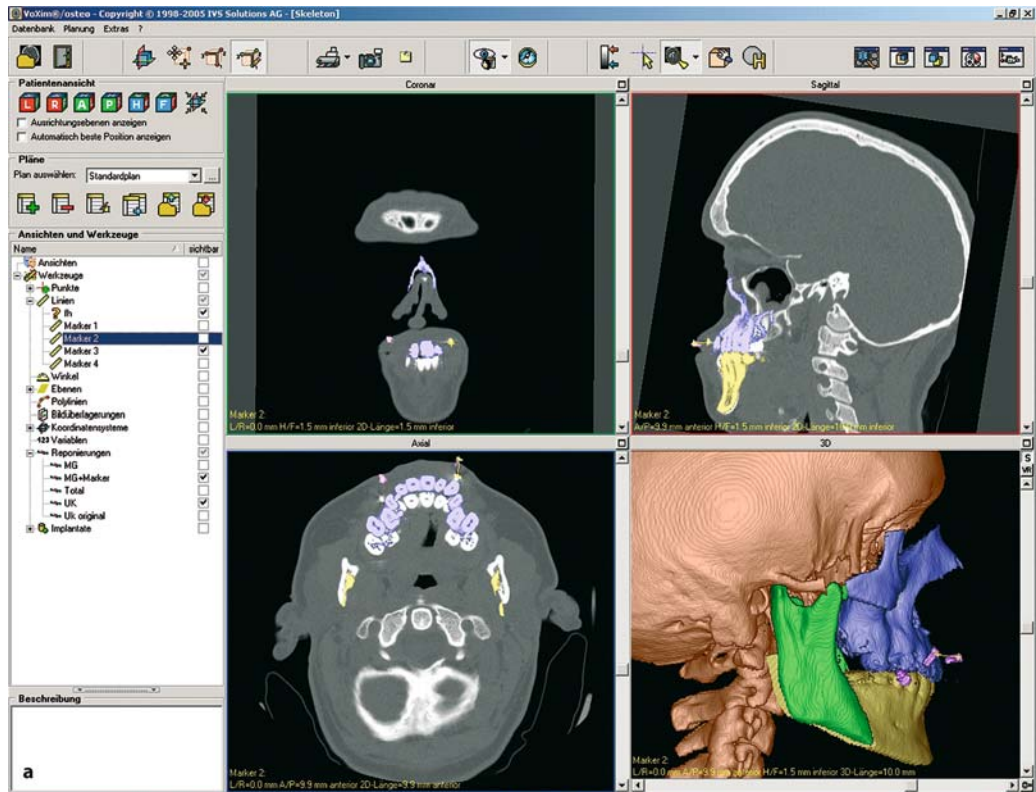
Facial correction in Crouzon's disease – transferring the CT plan to plaster models. Since the data set has been aligned on the hinge axis-orbital plane, it can be correlated with the articulated plaster models. The virtual advancement of the splint-based markers is determined by CT planning (a), and the desired mandibular correction is transferred to the plaster jaw model with the aid of a fully adjustable articulator (b). After the maxilla has been articulated in its new position, a surgical splint can be fabricated for midfacial advancement (c). A second surgical splint for the mandibular correction is made conventionally by moving the plaster models to the desired interocclusal relation (d)
